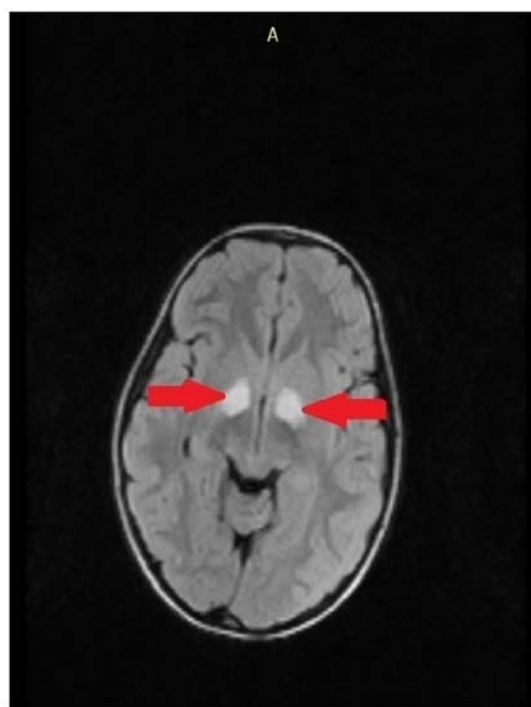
Anterior view of MRI showing FLAIR transversal section-midbrain hamartomas identified in an 8-year-old patient, obtained at the Clinical Hospital for Children, Galati, Romania. A, anterior view.
